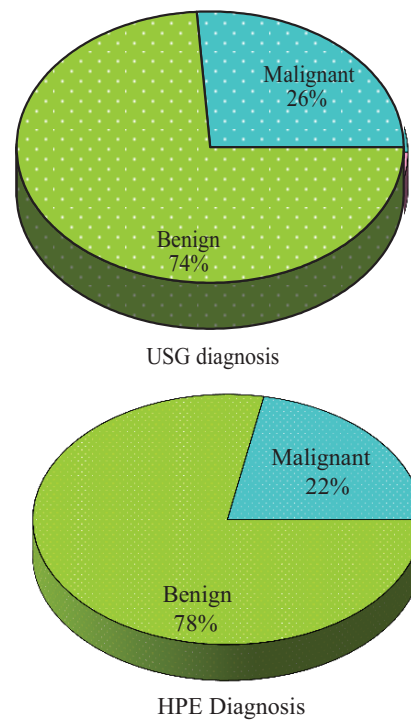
Ultrasound and HPE diagnosis in studied Group.
